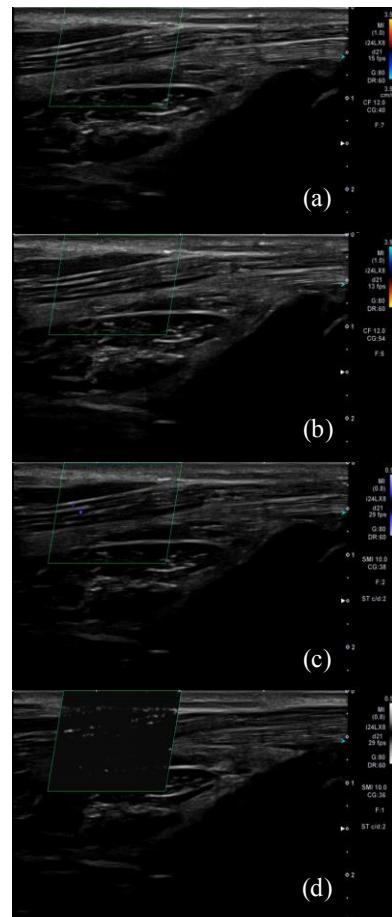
Evaluation of vascular features for a normal volunteer using (a) Color Doppler Imaging (b) Power Doppler Imaging (note, the color bar is the same as CDI) (c) Monochrome Superb Microvascular Imaging (d) Color Superb Microvascular Imaging.
